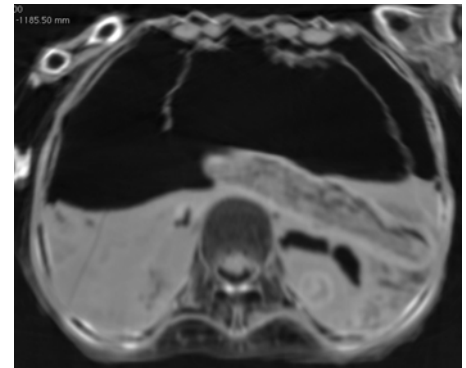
CT scan of the chest of Pa-Ib, showing the remnants of the incised diaphragm in the absence of the heart. (Sectioned 3D Reconstruction Above)
